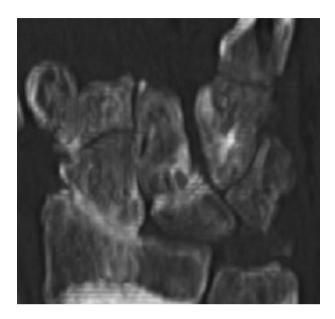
Coronal MIP CT. SLAC 2. Marked reduction in the thickness of the radioscaphoid articular cartilage with subchondral sclerosis
